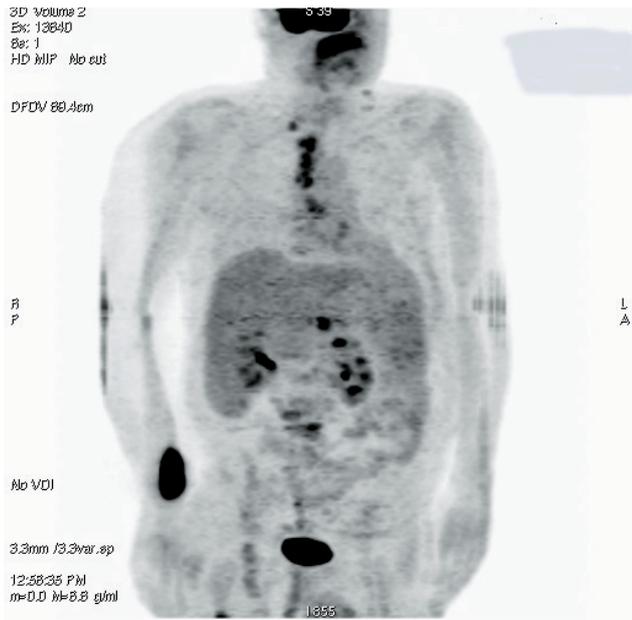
PET CT examination documents the lymphoma recurrence at the level of the mediastinal lymph nodes and in the lumbar spine.
